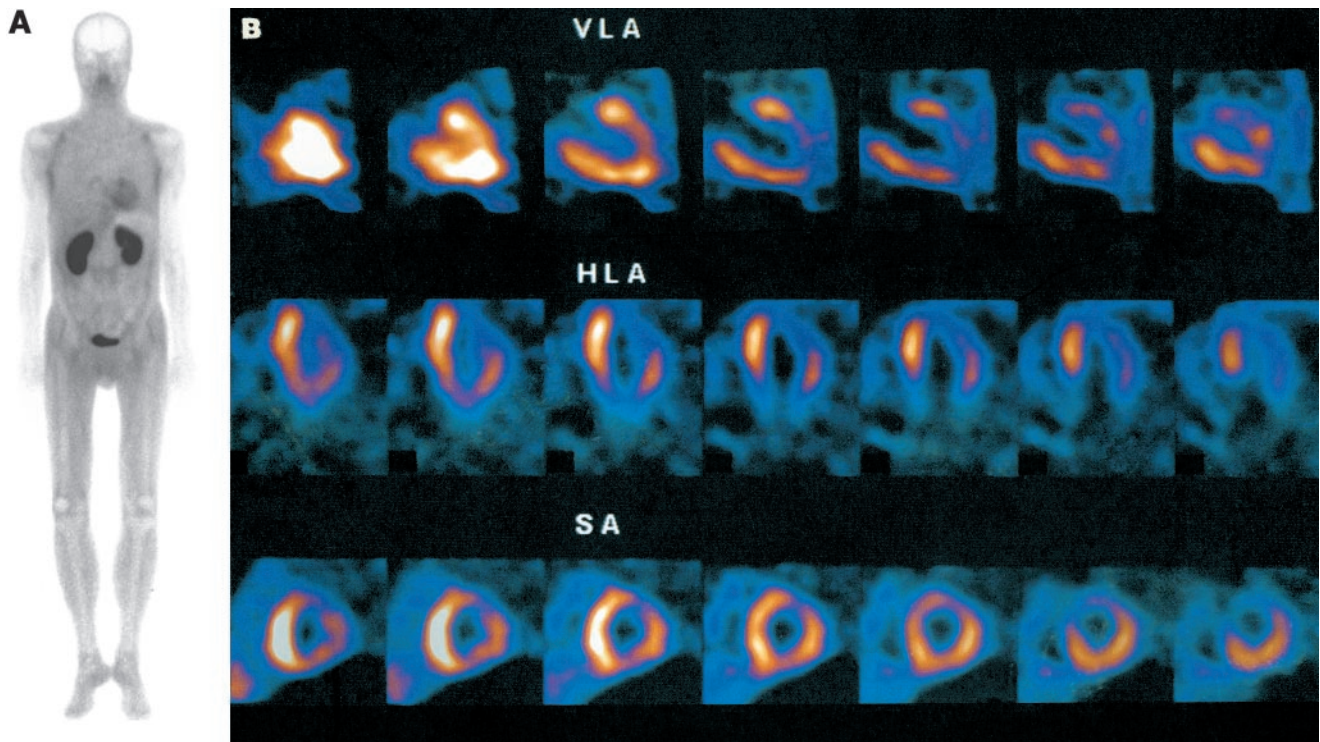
A 50-y-old man (patient 14) suffering from severe polyneuropathy during last year, slight functional dyspnea, and coughing. Biopsy of sural nerve showed unspecific axonal atrophy. His mother had died from polyneuropathy and amyloid cardiomyopathy. Scintigram shows pleural and cardiac accumulations of aprotinin (A, anterior view). (B) SPECT tomograms of chest show pronounced aprotinin uptake in interventricular septum and less pronounced uptake in lateral wall and apex of heart. VLA = vertical long axis; HLA = horizontal long axis; SA = short axis.
